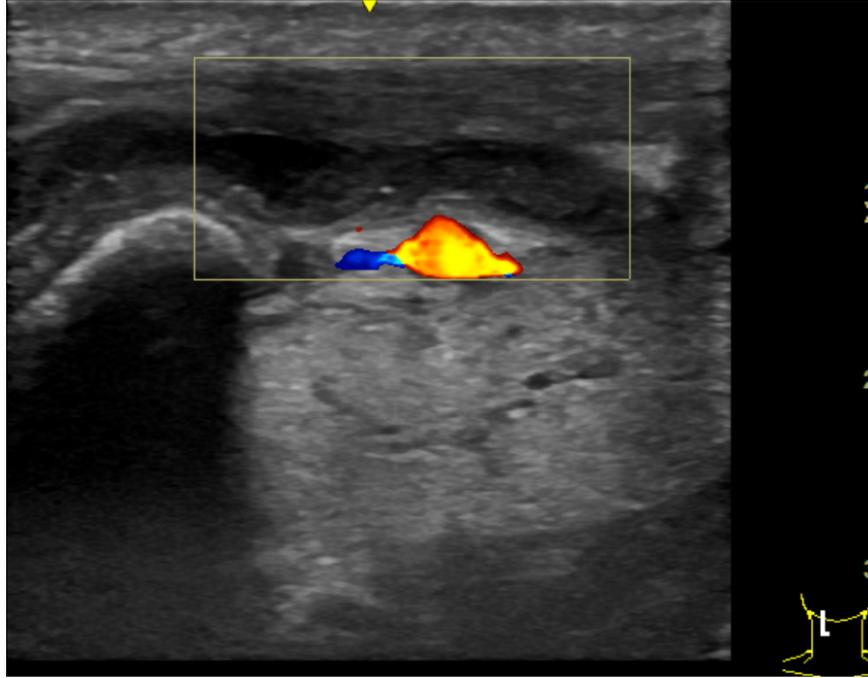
Ultrasound of the facial vein ©Fiedler LS.
